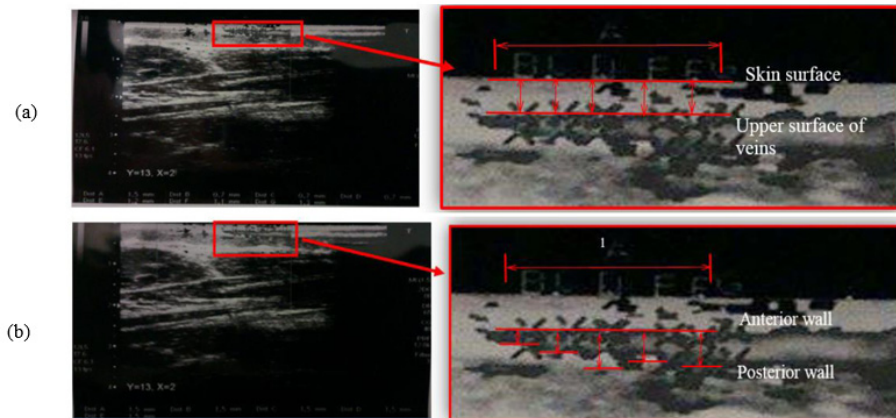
Ultrasound measurements: (a) depth, (b) thickness.
